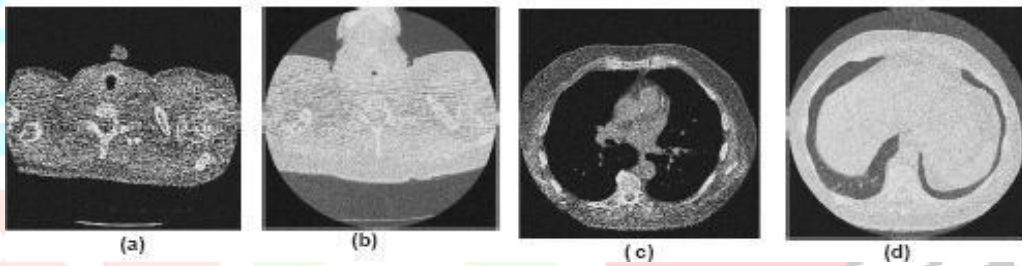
Noisy CT Image Data Set ( $\sigma = 20$ )
